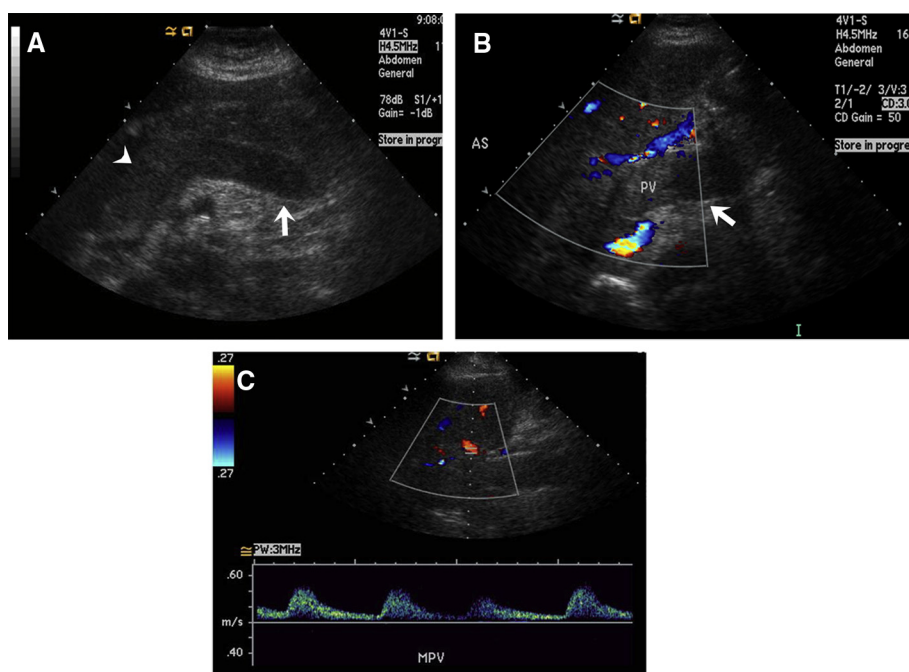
An 84-year-old male with pancreatic cancer. (A) Transverse grayscale ultrasound image showing echogenic tumour thrombus with expanded portal vein (PV; arrowhead) and splenic veins (arrow). Transverse color Doppler image showing absence of flow in the PV (arrow),B) and low-resistance arterial waveform seen in the main PV (C).
